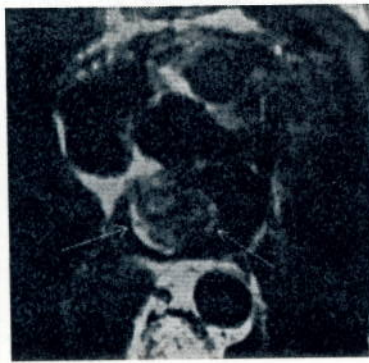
Left atrial myxoma. Transverse contrast enhanced T1-weighted image shows enhancement indicating the presence of a tumor and, thus, a left atrial myxoma. Since the mass enhances, the diagnosis of thrombus is excluded.
